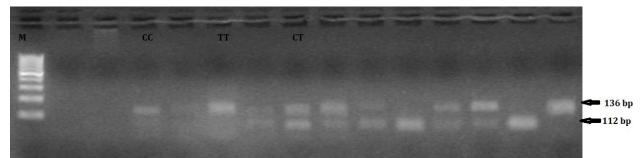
PCR-RFLP analysis of the TCF7L2 (rs7903146) locus revealed two bands of 112 bp and 24 bp in the TT homozygote genotype, one band of 136 bp in the CC homozygote, and three bands of 136 bp, 172 bp, and 24 bp in the CT heterozygote genotype. M = 100 bp ladder DNA marker.
